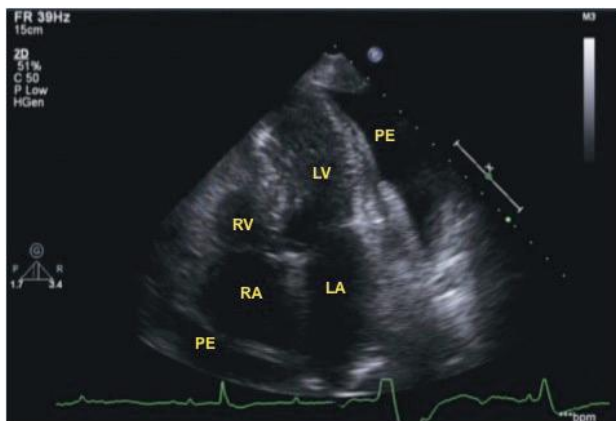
Apical four-chamber echocardiogram showing echo-free space consistent with moderate pericardial effusion: PE, pericardial effusion; RA, right atrium; LA, left atrium; RV, right ventricle; LV, left ventricle.
